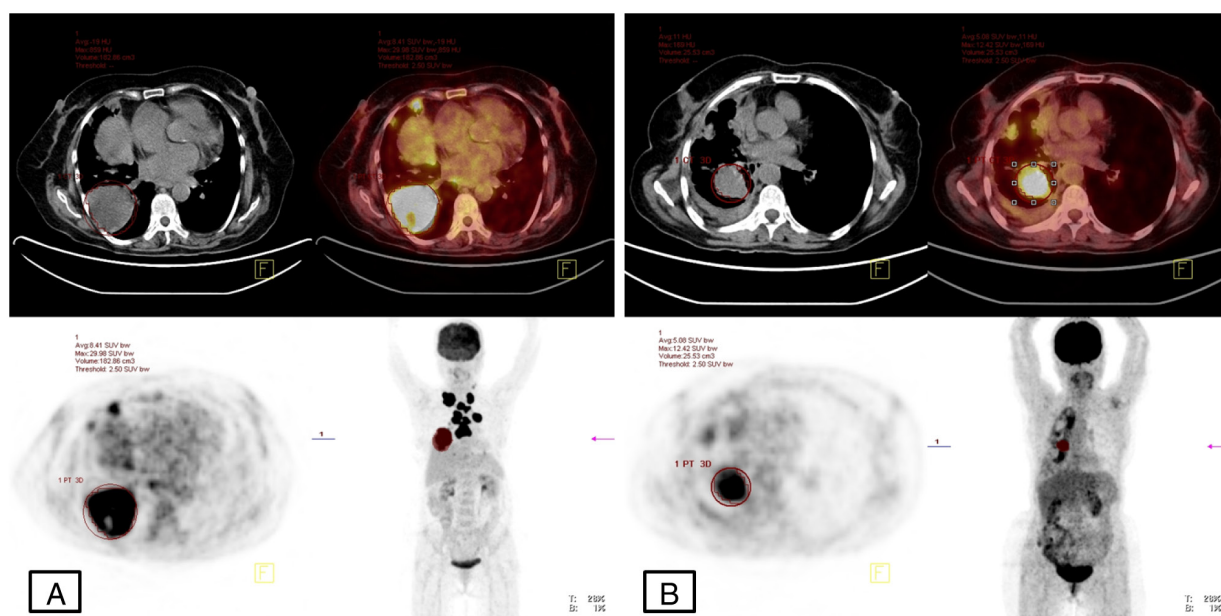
Representative F-18 FDG PET/CT images of patients with non-small cell lung cancer. (A) EGFR-positive case demonstrating primary tumor FDG uptake (B) ALK-positive case demonstrating primary tumor FDG uptake. FDG-PET/CT, ^{18}F -fluoro-2-deoxyglucose positron emission tomography/computed tomography.
